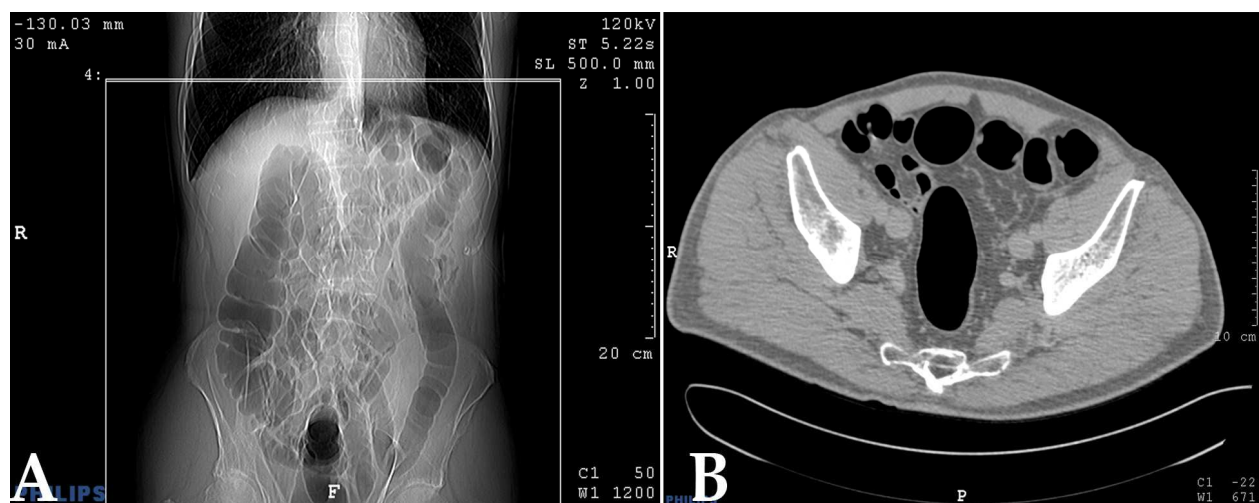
(A) Supine scout CT image and (B) 2D transverse CT colonographic image show adequate distension of colonic segments, allowing diagnostic examination.
